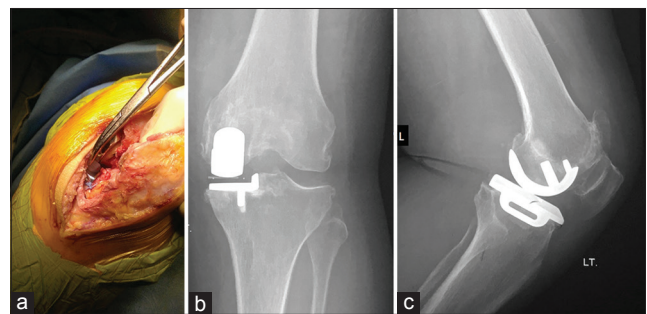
(a) Intraoperative picture showing the repair of avulsed anterior cruciate ligament using the using Ethibond suture. (b) Postoperative radiographs of the left knee in antero-posterior view showing the Oxford unicompartmental knee prosthesis *in situ*. (c) Lateral view showing the prosthesis *in situ* with no signs of anterior cruciate ligament laxity
